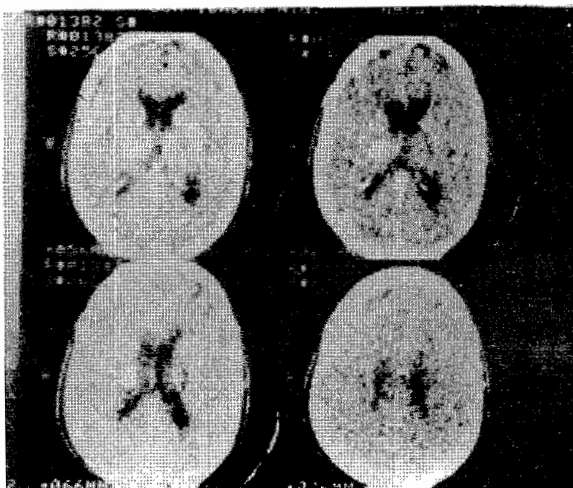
Contrast enhanced CT scan for patient number 1 showing nodular contrast enhanced right basal ganglia and thalamic mass.
